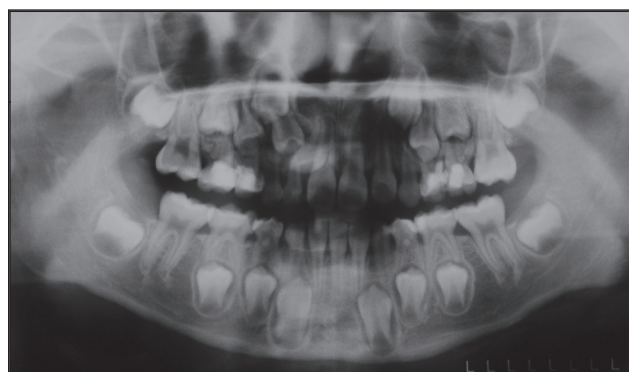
Case 1: A panoramic radiograph, taken at the age of 8 years, 7 months, shows a supplemental permanent maxillary right lateral incisor and congenital absence of the permanent mandibular right lateral incisor.
